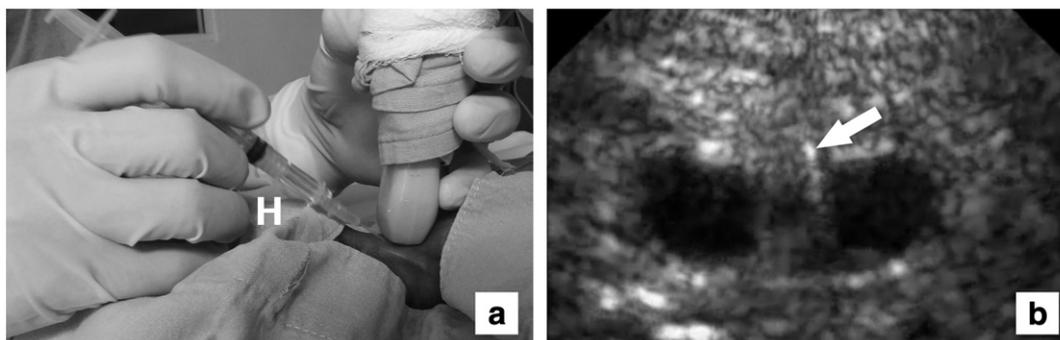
a. The puncture in the patient of Fig. 1 with a short 24-gauge intravenous catheter. b. The ultrasound image represents the short 24-gauge intravenous catheter tip (arrow) inside the right internal jugular vein.
